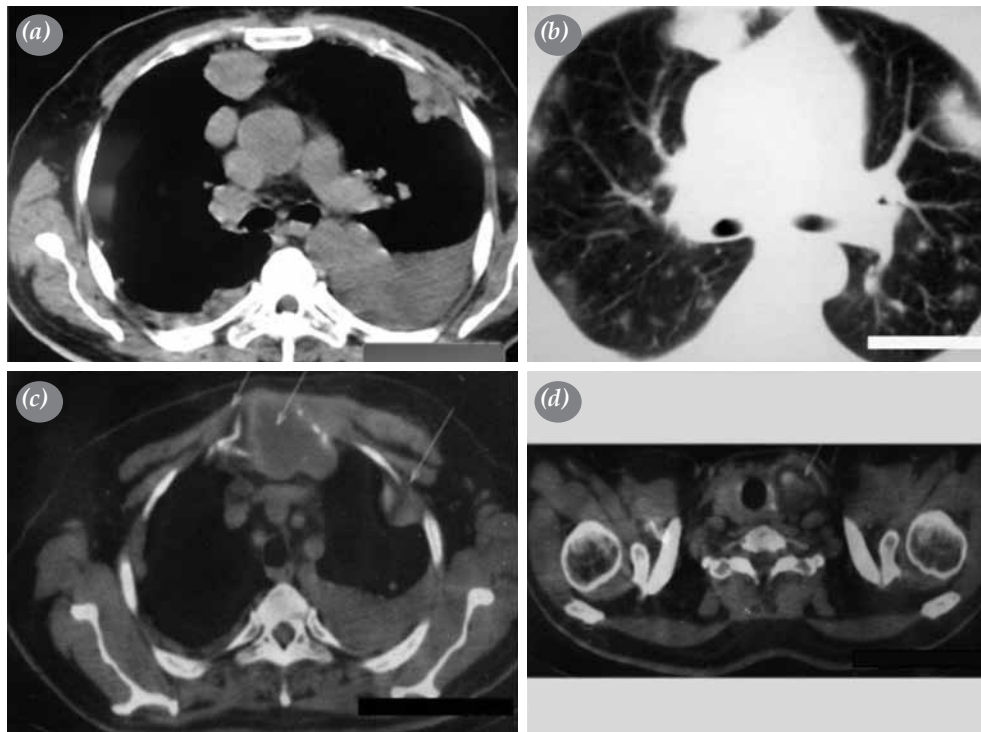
(a) Thoracic computed tomography showed enlargement of mediastinum with enlarged lymph nodes, bilateral pleural collection, and a subpleural opacification on left hemithorax. (b) Multiple coin lesions were seen in both lungs. (c) Positron emission tomography demonstrated mass behind sternum causing bone destruction showing high 18F-fluoro-2-deoxyglucose involvement that infiltrated retrosternal fat tissue and multiple parenchymal nodules including large mass on the left chest wall with pathological mediastinal and hilar lymph nodes. (d) Enlarged thyroid left lobe with high 18F-fluoro-2-deoxyglucose involvement was shown on positron emission tomography.
